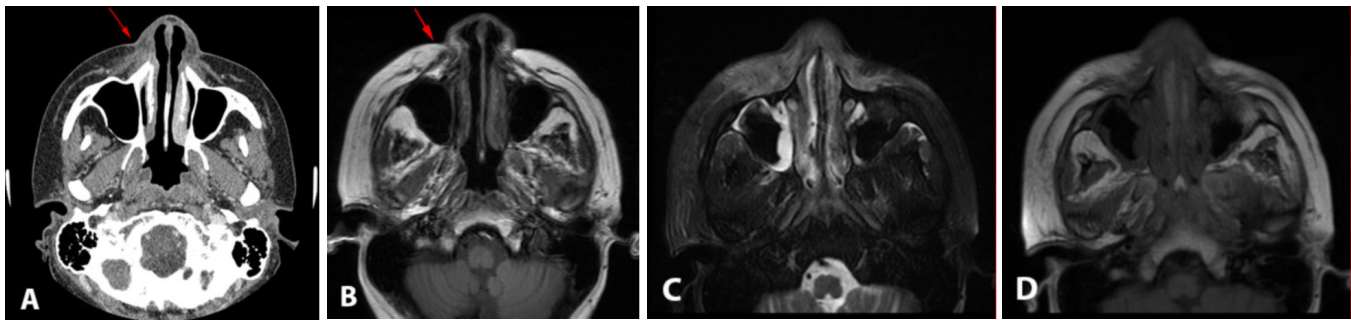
15-year-old male with hemophagocytic lymphohistiocytosis developed neutropenic fever and facial swelling following induction chemotherapy. (A) Noncontrast sinus CT and (B) T1-weighted MRI demonstrate right orofacial soft-tissue infiltration without sinonasal disease (arrows). T2-weighted (C) and T1-weighted (D) MRI on Day 4 demonstrate significant disease progression, with involvement of the nasal cavity and maxillary sinuses.
